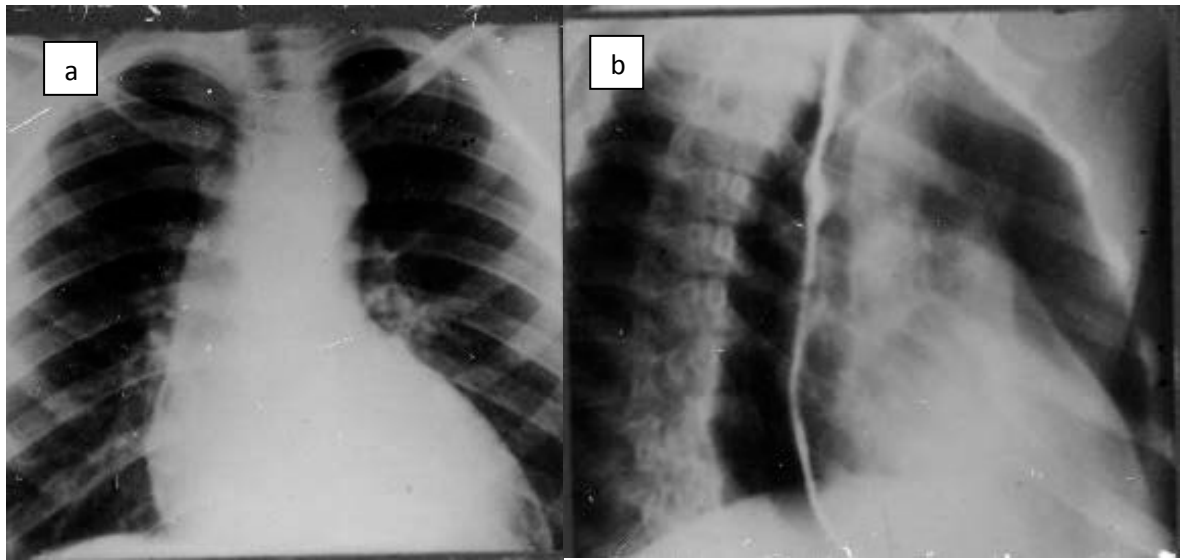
Heart radiographs in a direct (a), right (first) oblique projection (b); a) aortic configuration of the heart. Arches of the ascending aorta and left ventriculus in a direct projection are increased); b) in the right (first) oblique projection the bottom arch of a forward contour is formed left ventriculus is increased. Aortic stenosis [31]
